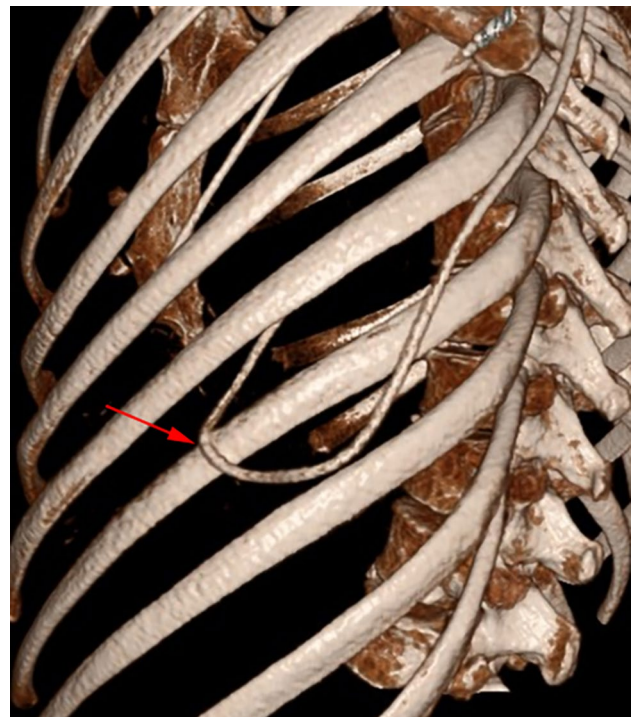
Three-dimensional CT images, showing the entry point of the pleural catheter over the eighth rib, marked by the red arrow.
